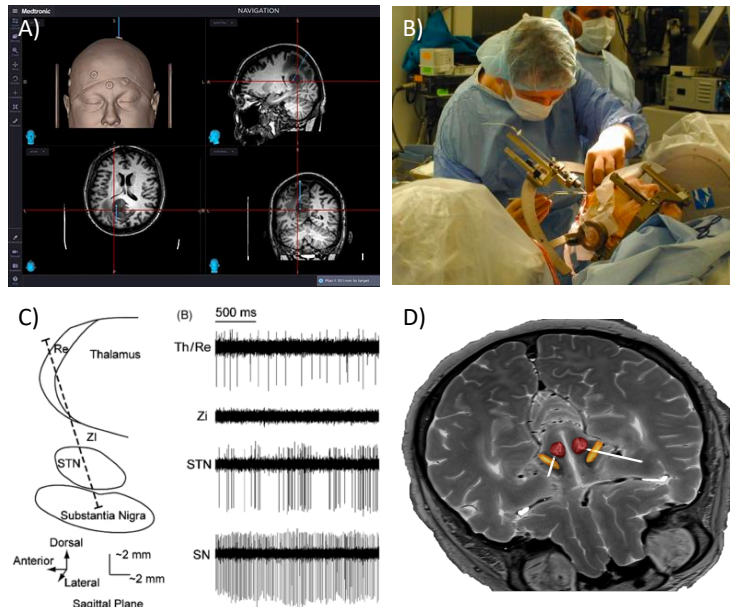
DBS Procedural overview. A) Surgery planning software from Medtronic using stereotactic pre-operative MRI. Image from reference [48] B) Example surgery photo after transferring patient to operating room, with stereotactic frame attached. Image from [49]. C) Microelectrode recording signals, showing characteristic burst-firing patterns from STN neurons. Image from reference [50]. D) Post-operative MRI reconstruction of a bi-lateral STN implantation using LeadDBS software. Yellow structure and red structures are the segmented regions of the STN and SN, respectively.
